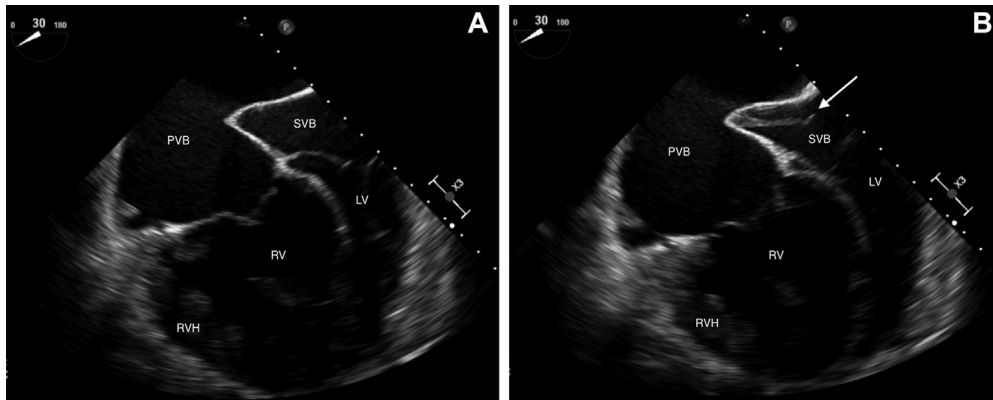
TEE, midesophageal view at 30°, showing a four-chamber view equivalent to the transthoracic view seen in [Figure 1](#). Right ventricular hypertrophy (RVH) is better appreciated on TEE, however. (A) No evidence of IE is initially seen. (B) After careful angulation toward the more anterior systemic venous baffle (SVB), a large echodensity concerning for IE is noted (*arrow*). LV, Left ventricle; PVB, pulmonary venous baffle; RV, right ventricle.
